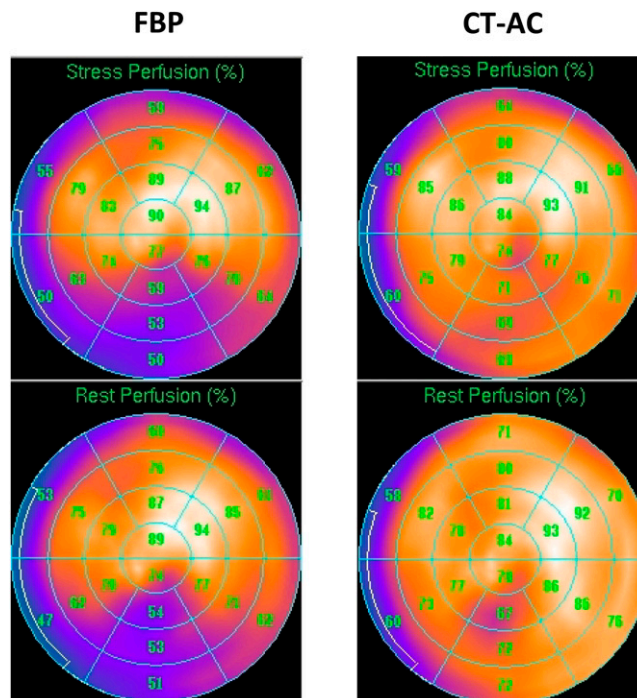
MPI polar map showing inferior attenuation artifact with FBP, which is resolved by applying CT-AC.
